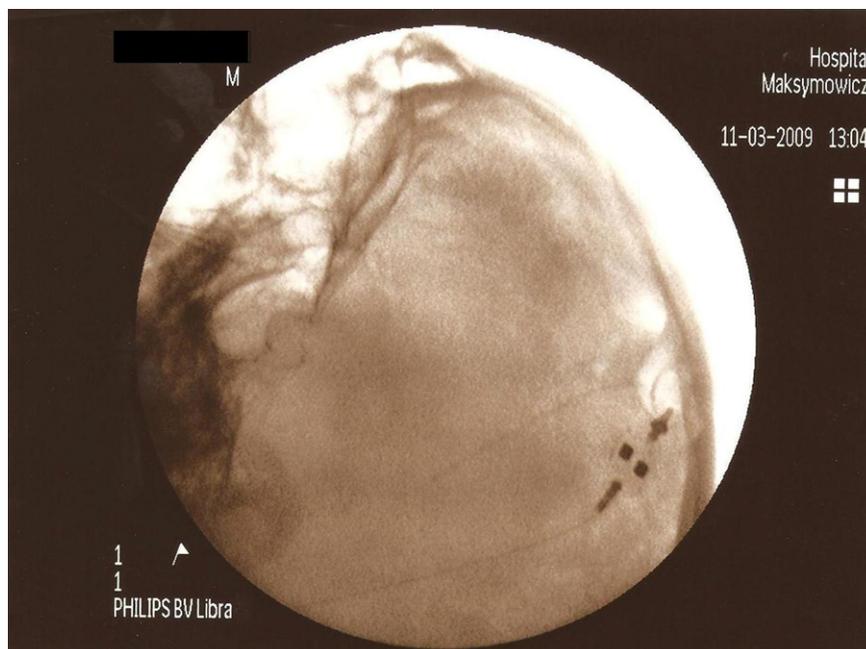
X-ray of the ventriculoperitoneal shunt to control valve opening pressure settings.
